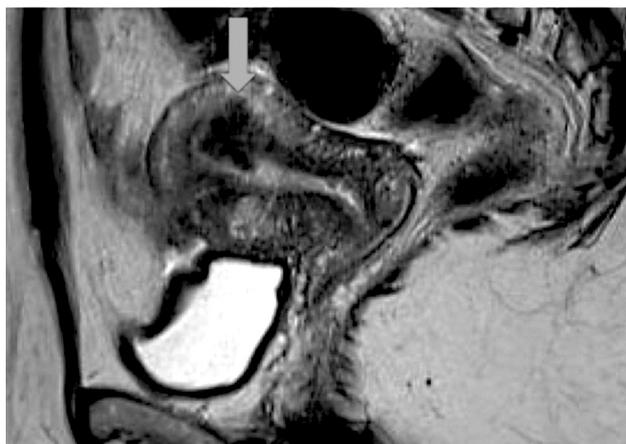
MRI performed after first pregnancy. Sagittal T2 MRI shows a hypointense mass corresponding to previous known endometrial mass (red arrow).
